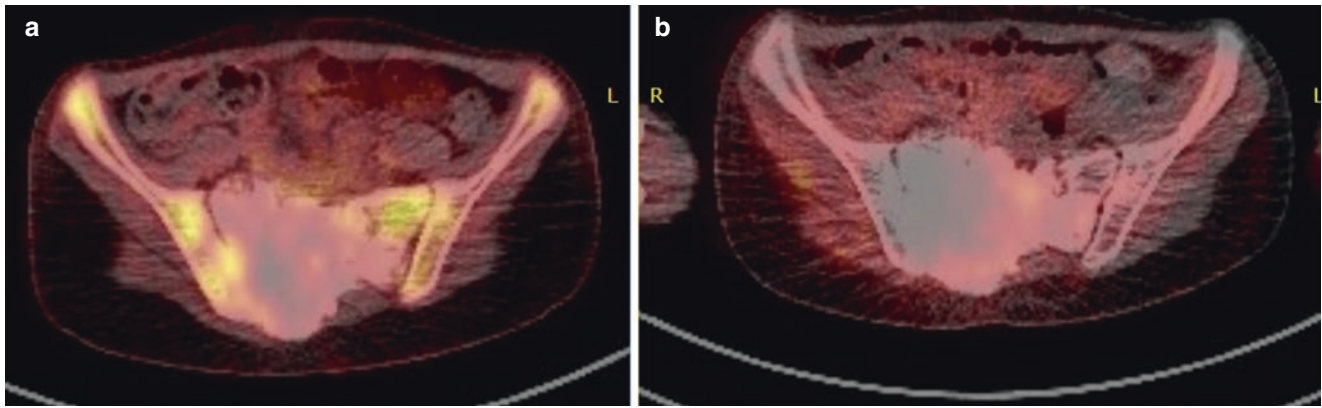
(a, b) Representative axial slices from PET/CT before and after radiosurgery for metastatic osteosarcoma of the femur for a pediatric Patient A
